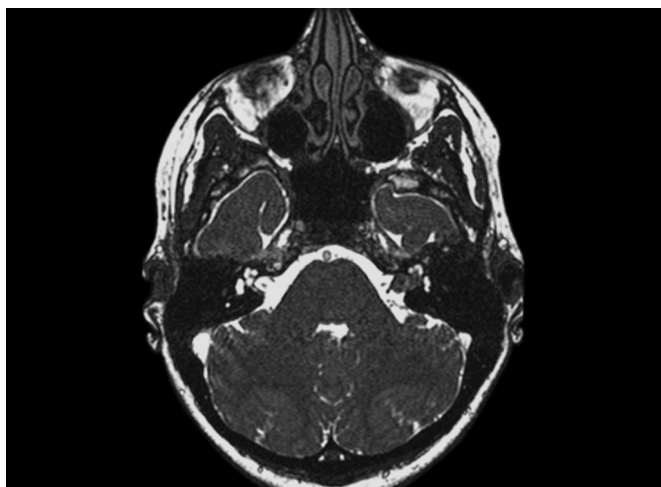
Vestibular schwannoma involving the distal intracanalicular. The constructive interference in steady state gradient-echo T2 MRI sequence shows no spinal fluid separating the lateral extension of the left-sided tumor from the cochlea and labyrinth. We chose a TLAB approach for this patient who presented with class C hearing.
